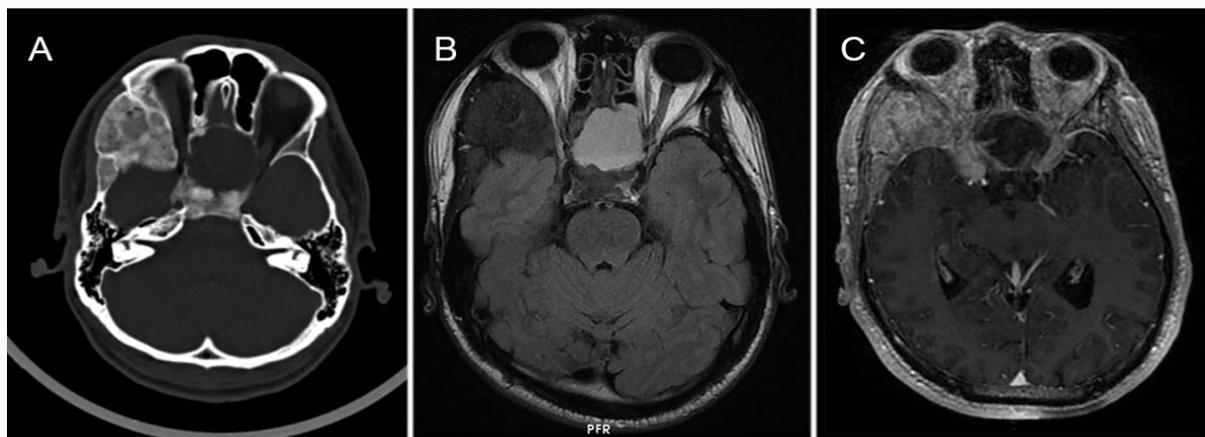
CT image showing a bone diffuse enlargement of the major and minor wings of the right sphenoid, pterygoid process and body of the sphenoid, involving all the sphenoidal sinus.
